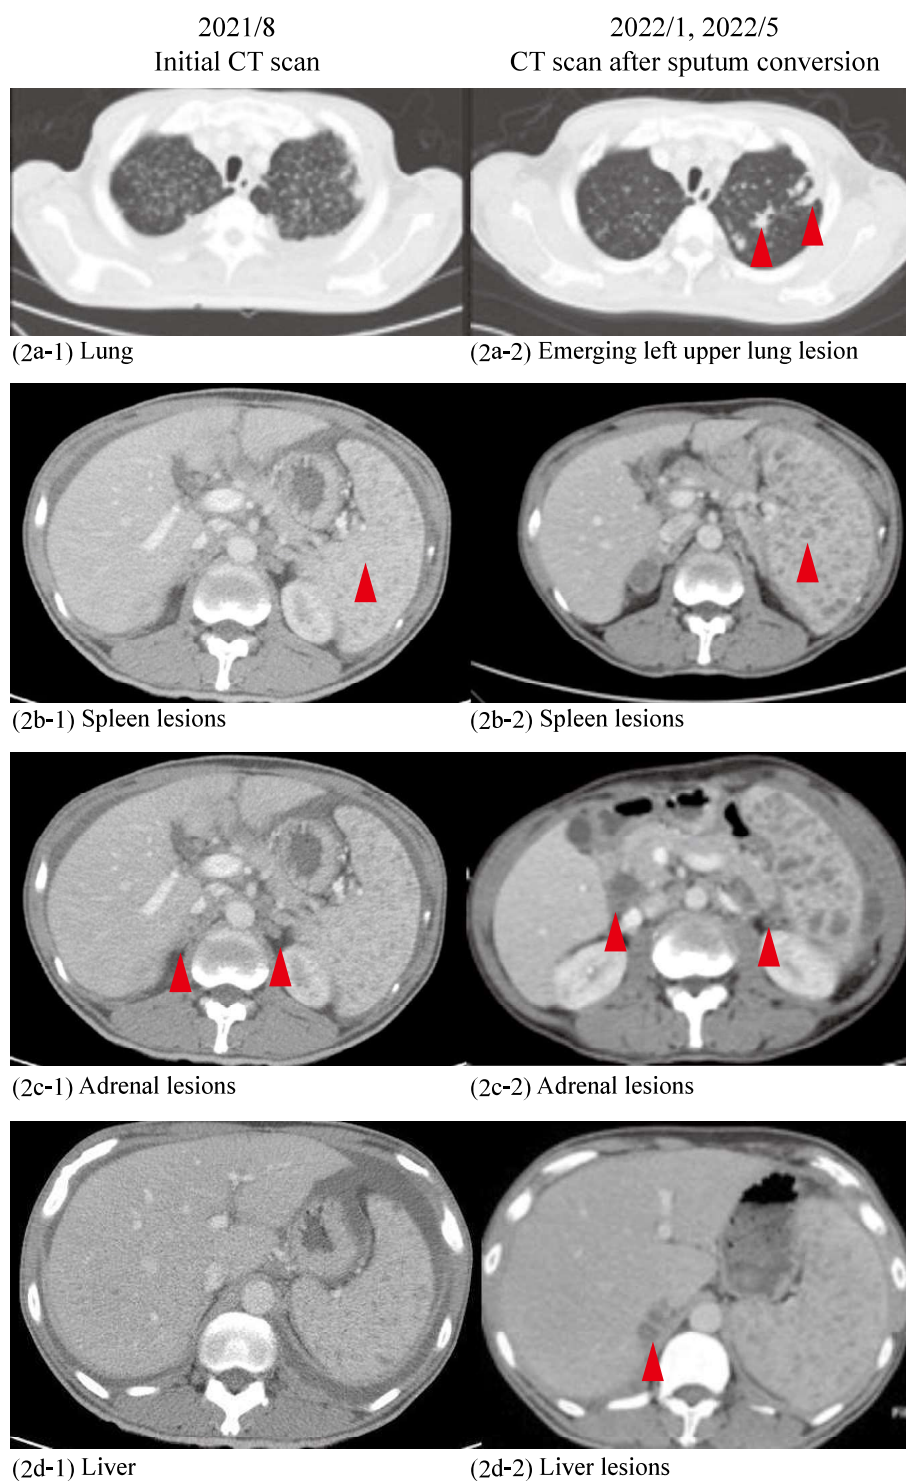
Computed tomography images of miliary tuberculosis at diagnosis and post-sputum conversion following anti-TB treatment: assorted by lesion sites.
